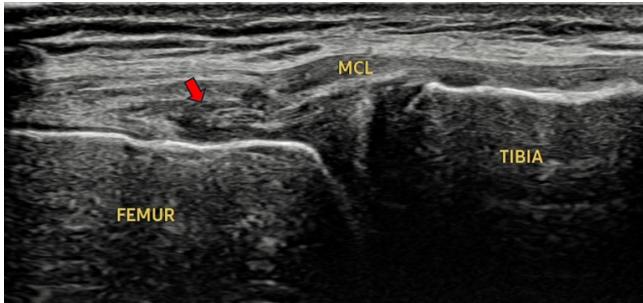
Ultrasound finding of right MCL, shows hypoechoic lesion over the proximal MCL (red arrow).
